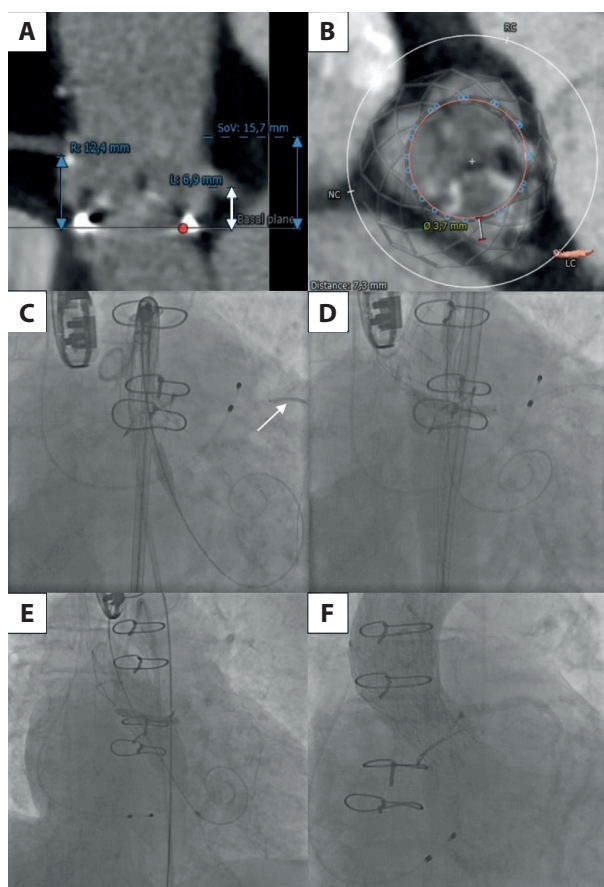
Low height of the LCA ostium on CT (A, white arrow) and small valve to coronary distance (B). Flaring of the Evolut R valve (C), a visible stent parked in the LAD (C, white arrow). Expansion of the stent extending from the LCA into the aorta (D). Postdilatation with a non-compliant 20-mm Gold balloon with simultaneous stent dilatation (E). The optimal procedure effect — the implanted Evolut R valve and patent LCA ostium with the use of DES (F) by the chimney stenting technique, preserved coronary blood flow
